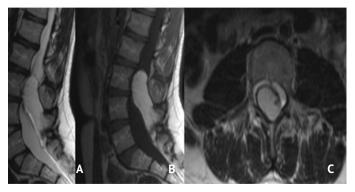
Lipoma at intradural location between L3-L5, MRI sections A) T2-weighted MRI, sagittal section, B) T1-weighted MRI, sagittal section, after IV contrast injection, C) T2-weighted MRI, axial section
